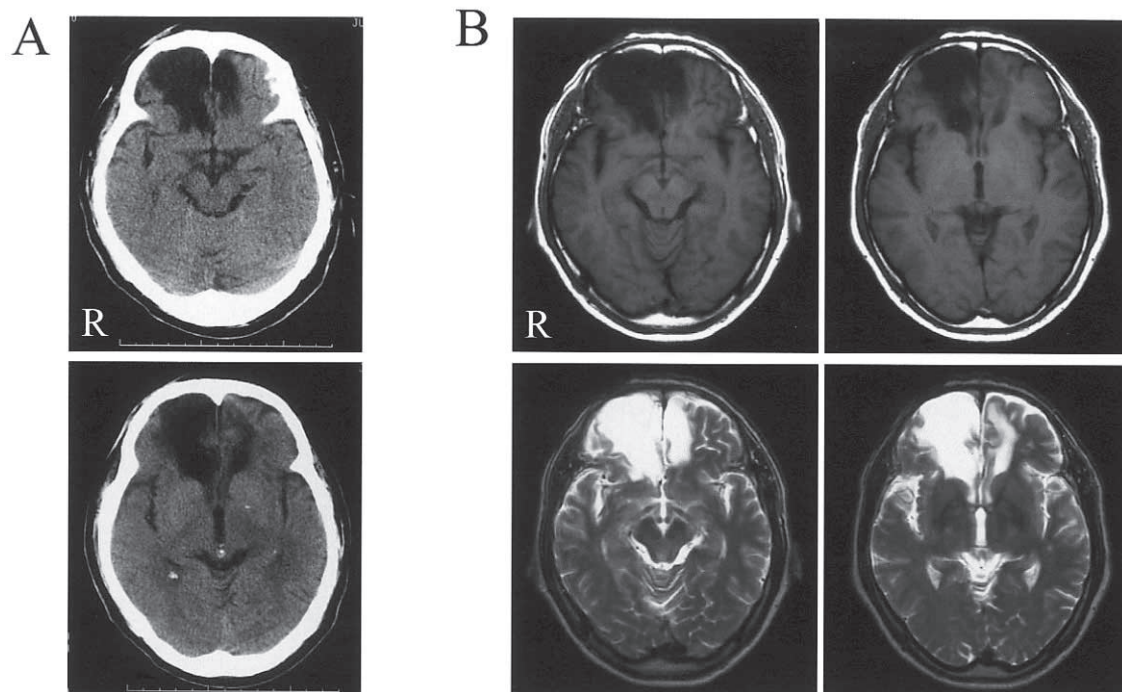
(A) CT scan immediately after admission showing large and small low density areas in the right frontal and left frontal lobes respectively. (B) Axial T1- and T2-weighted MRI images on the day after admission showing low and high intensity lesions in the same area as that shown in the CT scan.
